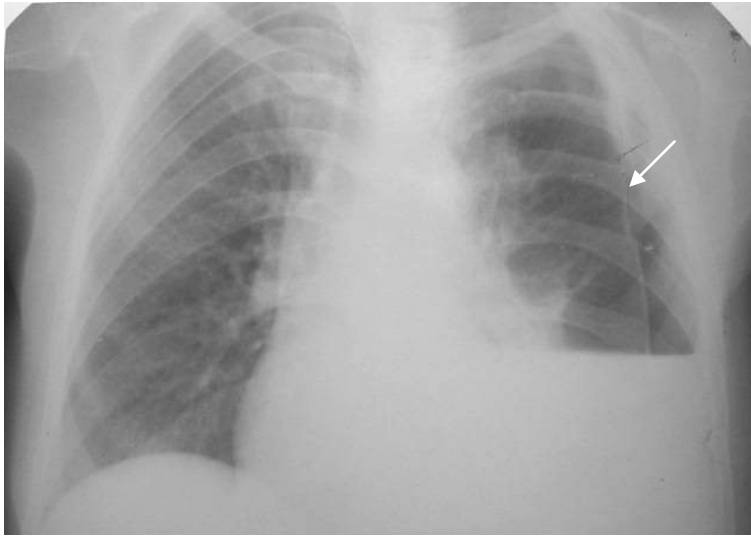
The frontal chest radiograph. In the lower department of the right pulmonary field intensive homogeneous shadow with distinct horizontal top level. In lateral part of the left pulmonary field a radiolucent zone without elements of pulmonary vessels. The left lung in passive atelectasis (arrow). Mediastinum is displaced to the right. Pneumothorax and hydrothorax on the left
